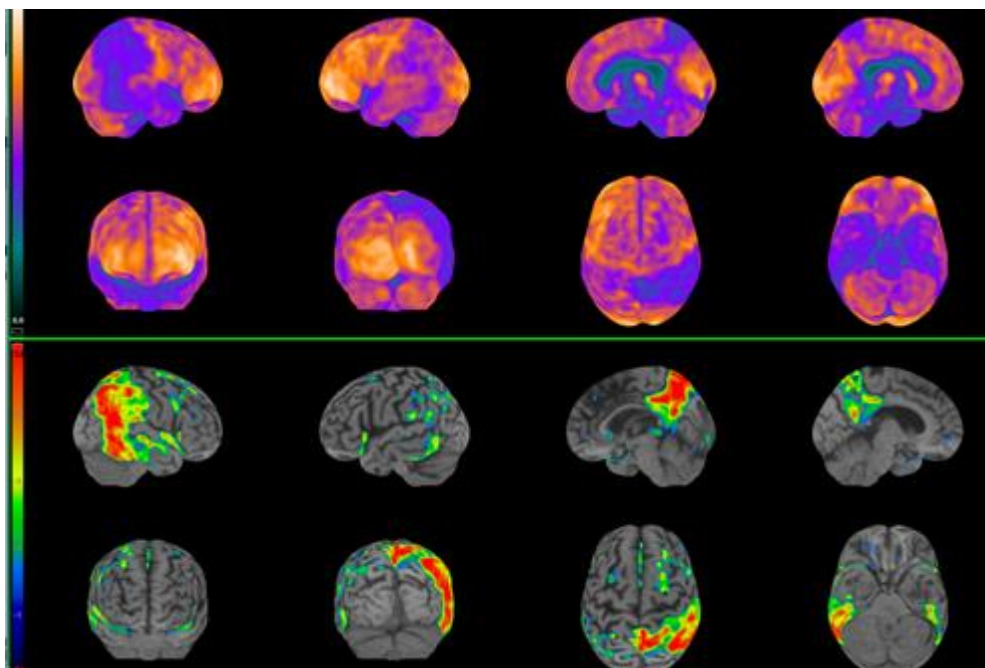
FDG-PET disclosing AD hypometabolic pattern
